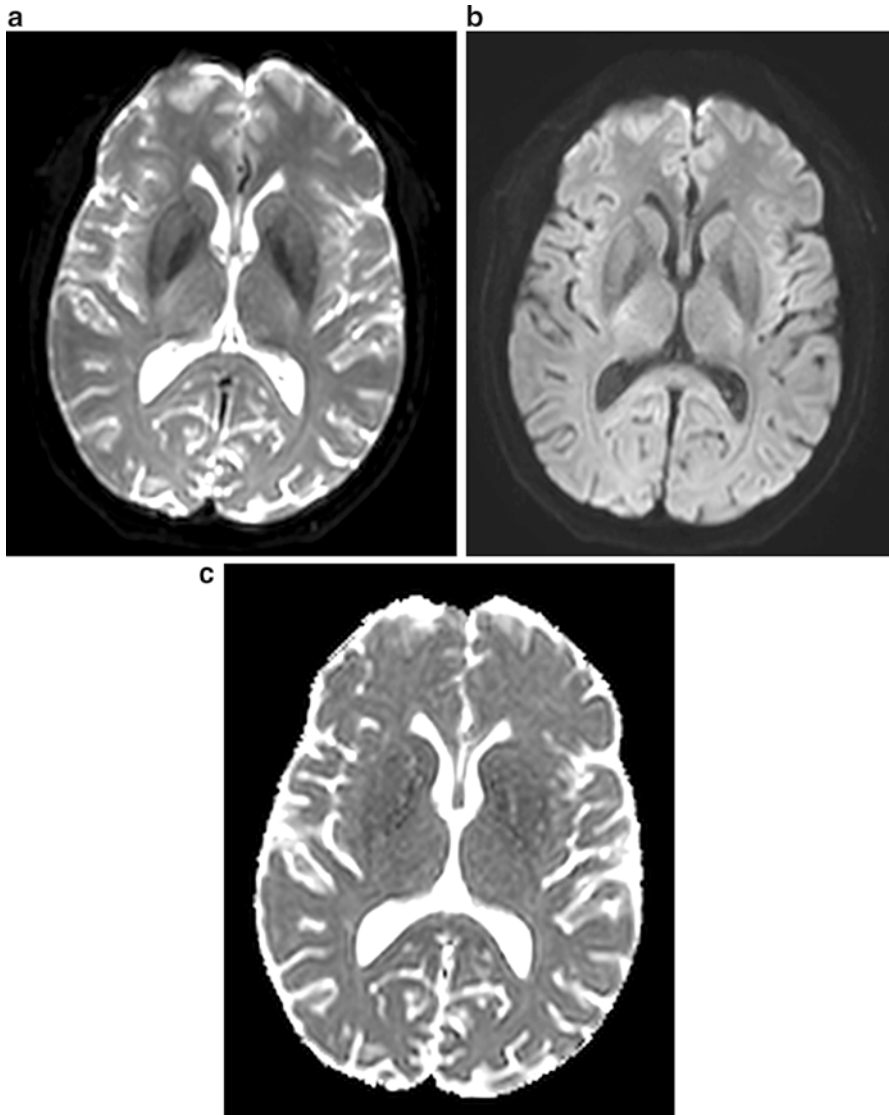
(a) Diffusion-weighted MRI: axial DWI image of the human brain with $b = 0 \text{ s/mm}^2$, (b) with $b = 500 \text{ s/mm}^2$, and (c) corresponding calculated ADC map
